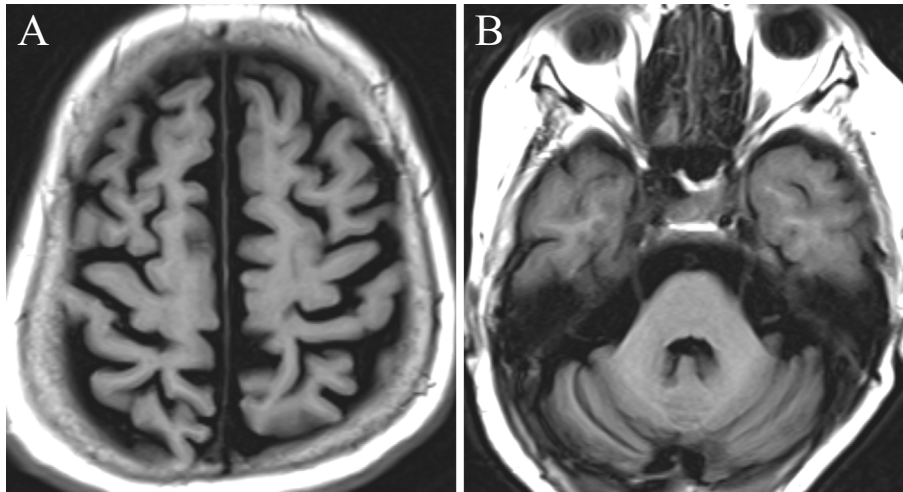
Brain magnetic resonance imaging (MRI). Brain MRI showing cerebral and cerebellar atrophy on axial T1-weighted images (A and B, respectively).
